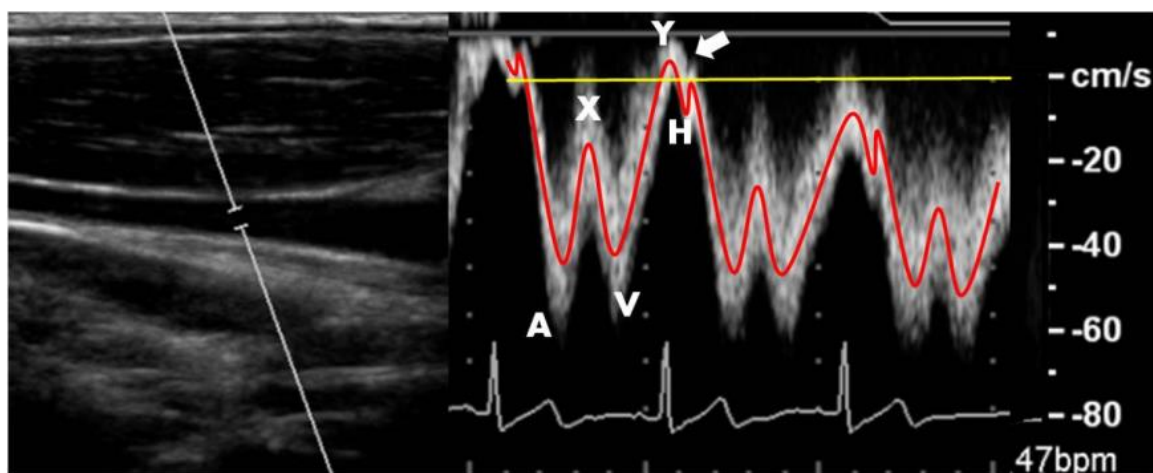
Left: B-mode anatomic location of right IJV blood flow. Right: Doppler ultrasonography displays triphasic IJV blood flow waveform as indicated in Figure 3-2. Arrow indicates minor normal reflux during the tricuspid valve reopening.
